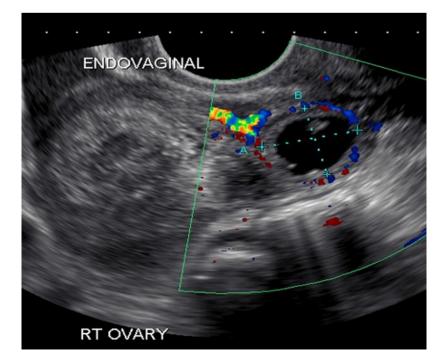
Ultrasound imaging of tubal pregnancy
